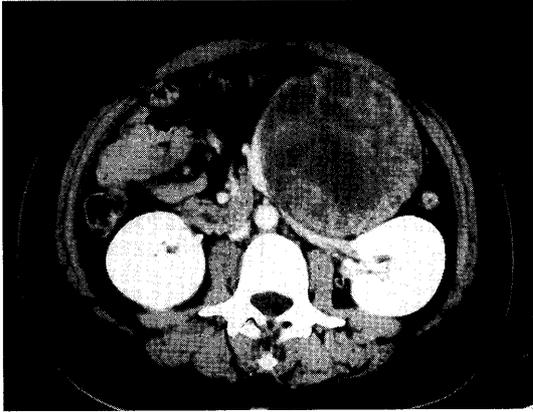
Abdominal CT image showing a well-defined, round, 10 cm mass with calcification compressing the left renal vein
